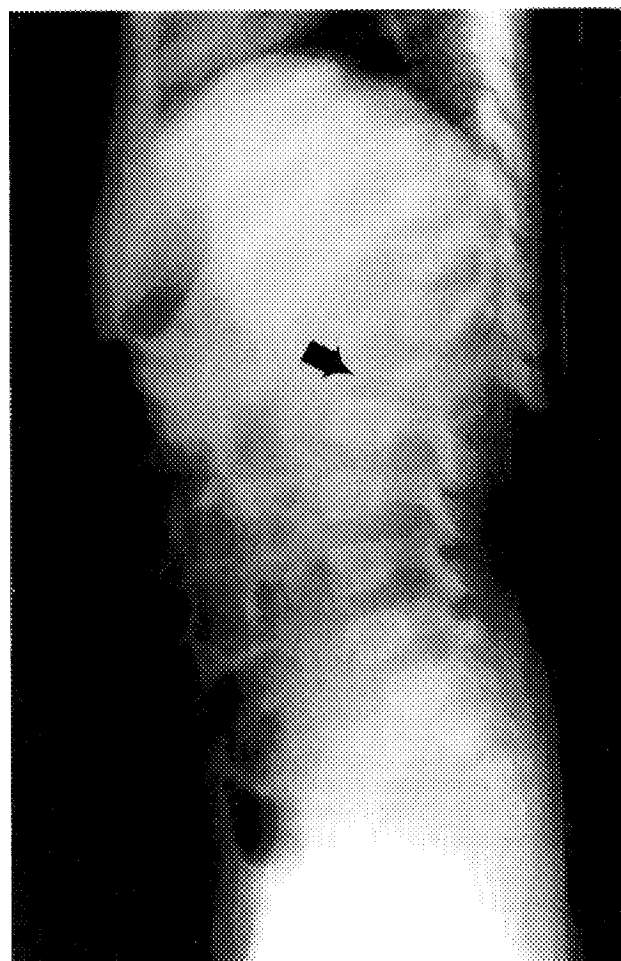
Lateral radiograph demonstrates a complete anterior fracture-dislocation through the L1-L2 interspace (arrow), with fracture of the spinous process and superior facets of L2.
